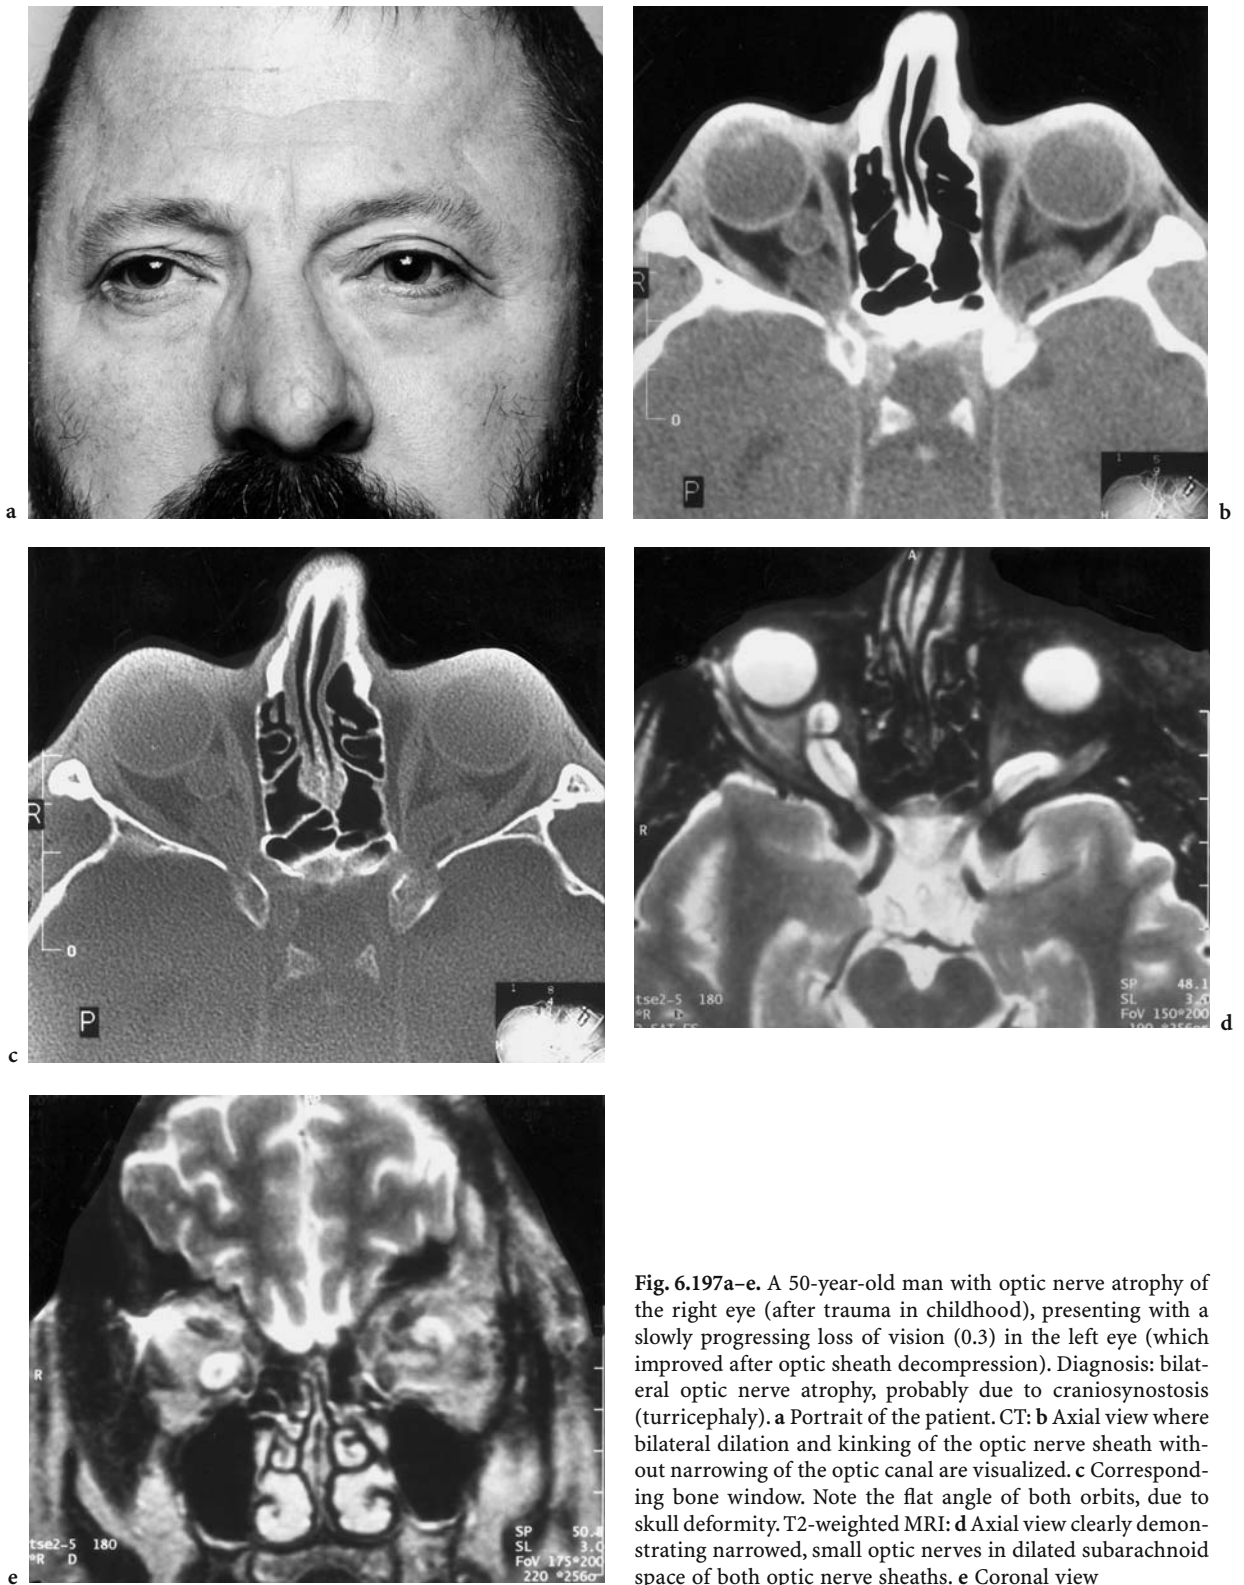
A 50-year-old man with optic nerve atrophy of the right eye (after trauma in childhood), presenting with a slowly progressing loss of vision (0.3) in the left eye (which improved after optic sheath decompression). Diagnosis: bilateral optic nerve atrophy, probably due to craniostenosis (turricephaly). a Portrait of the patient. CT: b Axial view where bilateral dilation and kinking of the optic nerve sheath without narrowing of the optic canal are visualized. c Corresponding bone window. Note the flat angle of both orbits, due to skull deformity. T2-weighted MRI: d Axial view clearly demonstrating narrowed, small optic nerves in dilated subarachnoid space of both optic nerve sheaths. e Coronal view
